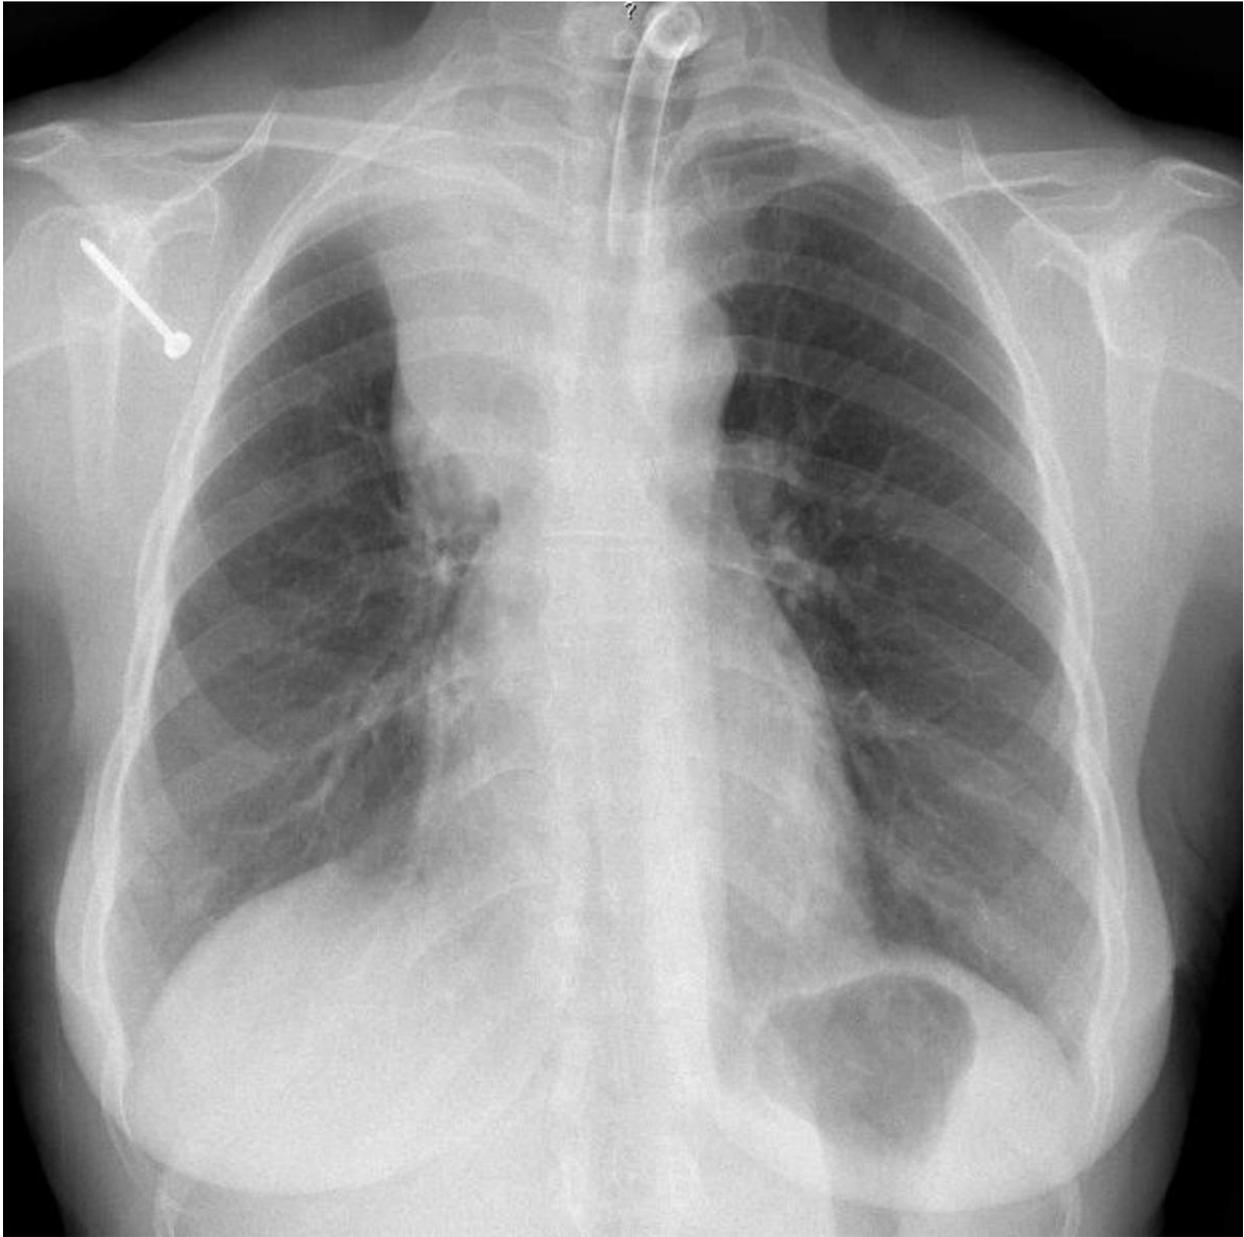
WESTERMARK SIGN - PA chest radiograph of a patient with pulmonary embolism: There is an area of pulmonary radiolucency at the medial half of the upper field of the left lung - the Westermark sign.
